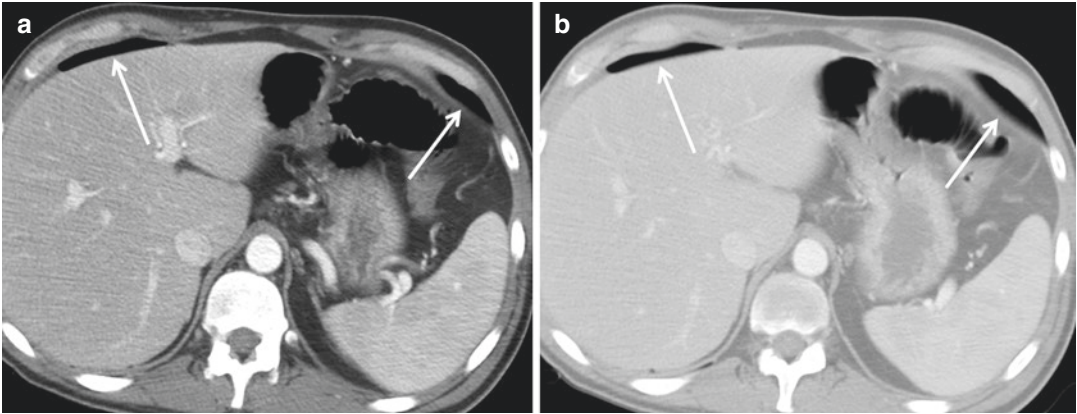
Axial CT contrast-enhanced scan shows free air from bowel rupture laying behind the anterior abdominal wall, along the anterior surfaces of liver and spleen
